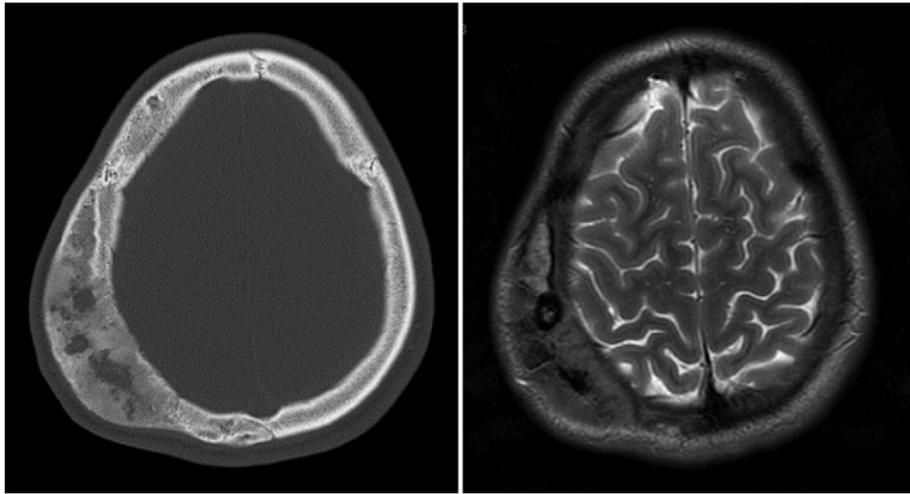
A right parietal bone lesion is seen on axial CT scan (left panel) and T2-weighted axial MRI (right panel), without underlying brain compression.
